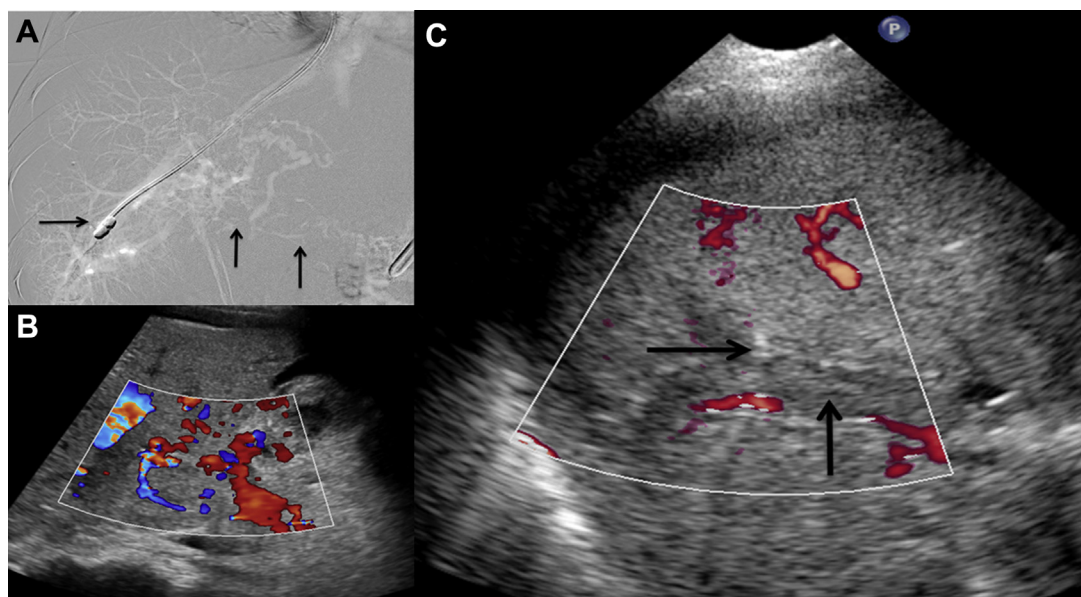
(A) CO₂ portovenogram through balloon catheter (horizontal arrow) in the right hepatic vein demonstrates nonvisualization of the portal vein and multiple collaterals in the region of portal vein (vertical arrows). (B) Doppler ultrasound of the liver demonstrates no flow in the portal vein with multiple collaterals around it suggesting cavernous transformation. (C) Demonstrates advancement of the Colapinto needle (horizontal arrow) under ultrasound guidance into the thrombosed right branch of portal vein (vertical arrow).
